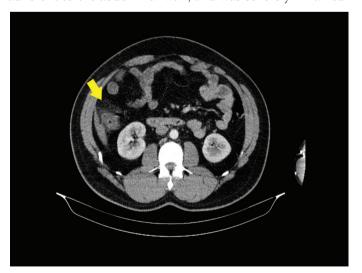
A 32-year-old-man with abdominal pain was admitted to the emergency department. CT scan showed an inflamed area around the hepatic flexure at the liver border
